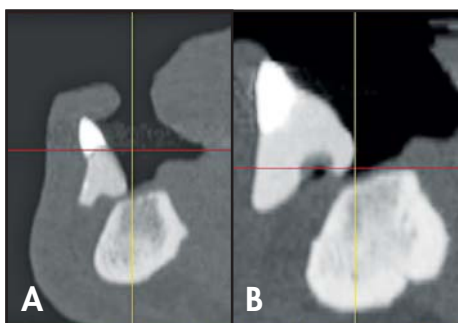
Initial CT scan of the mandible with a third-generation scanning appliance in place. 15B. Second CT scan showed that the incisal edge correctly bisected the vestibular fornix.
